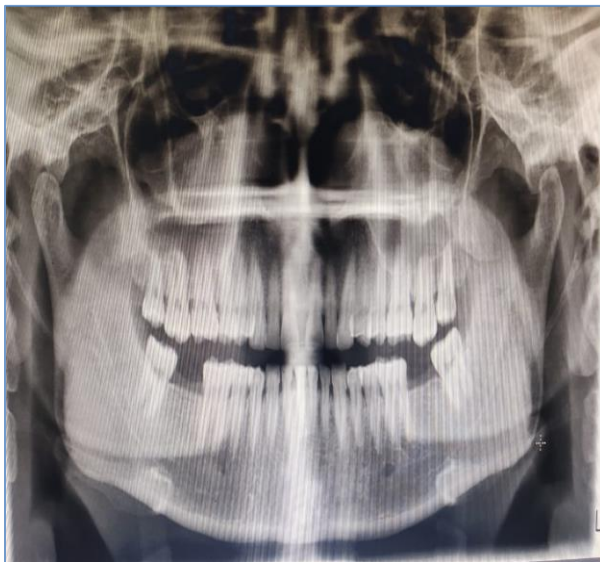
Panoramic radiograph showing elongated styloid process on left side.
